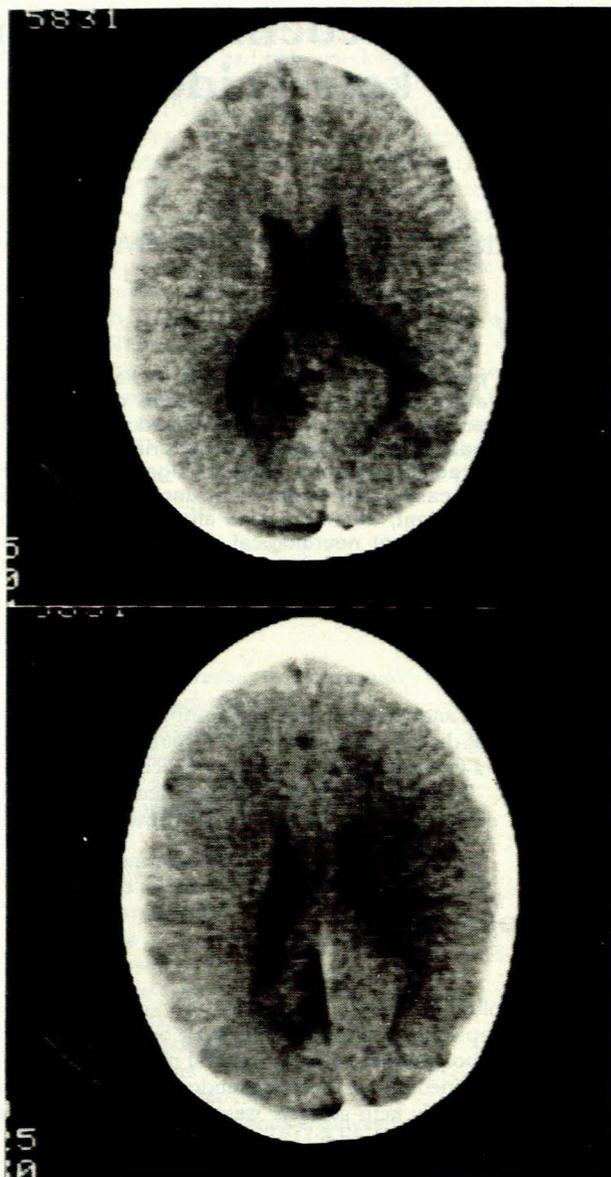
CT without contrast medium, demonstrating return of grey-white differentiation and return of lateral ventricular size to normal limits (above). CT without contrast medium, demonstrating focal atrophy in the left occipital lobe corresponding with the resolving gliomasideral response and spongiosis of the posterior cerebral infarct (below).
